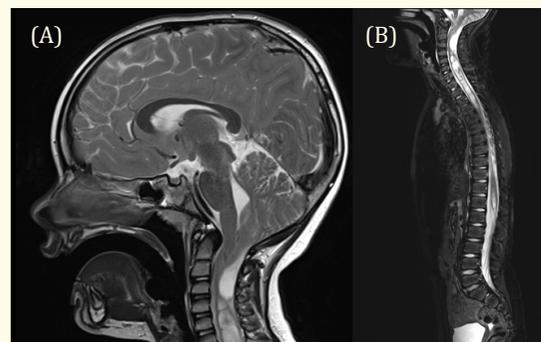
T2-weighted MRI images of the lateral brain (A) and spine (B) demonstrating Arnold-Chiari type I malformation with extensive syringomyelia from C4 to T12.
